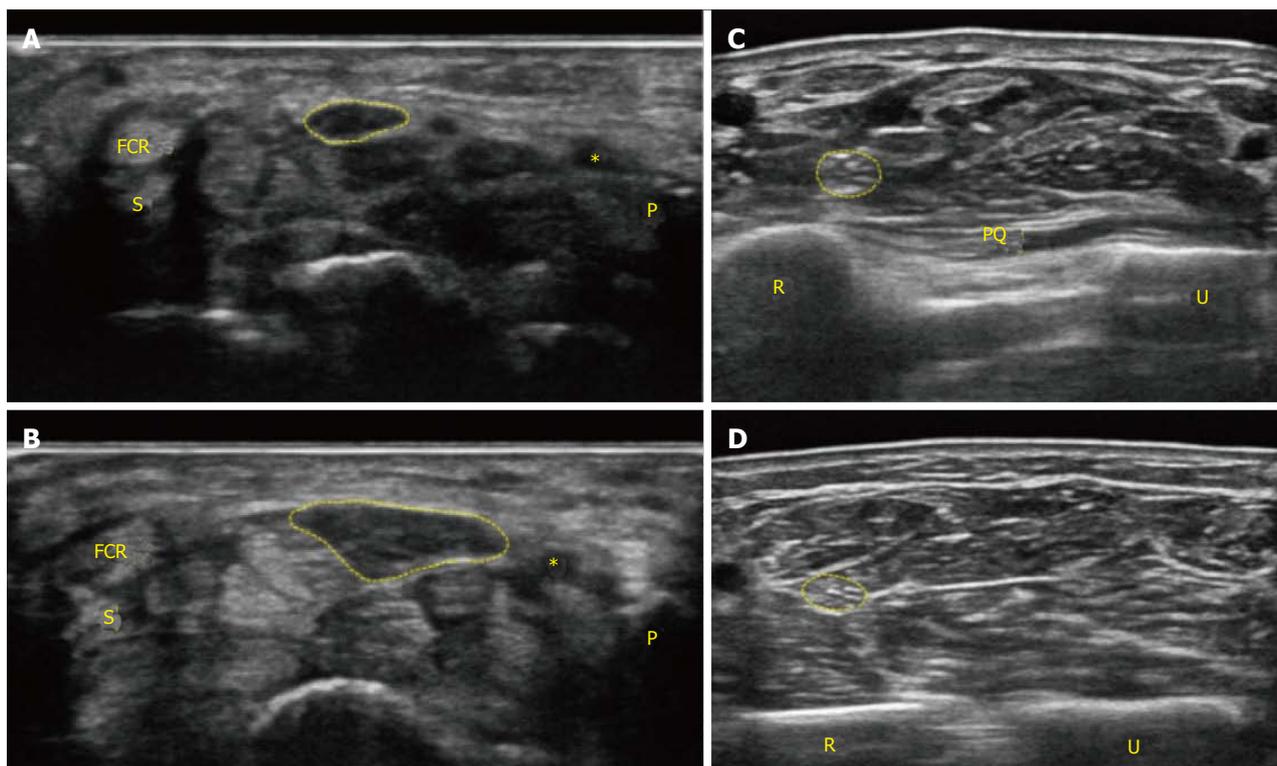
Transverse images in a 79-year-old female with carpal tunnel syndrome. A: A conventional grey scale sonographic image shows the cross-sectional area of the median nerve (CSA) corresponding to the circle in the normal side with an area of 8 mm² at the level of the pisiform bone; B: CSA in the carpal tunnel syndrome (CTS) side shows 21 mm² at pisiform bone level; C: CSA in the CTS side shows 7 mm² at the proximal third of the pronator quadratus level; D: CSA in the CTS side shows 6 mm² at a point 12 cm proximal to the pisiform bone. In this case, the calculated “delta CSA” and “CSA ratio” were 14 mm² and 3.5, respectively. *: Ulnar artery. FCR: Flexor carpi radialis; P: Pisiform bone; S: Scaphoid bone; PQ: Pronator quadratus muscle; R: Radius; U: Ulnar.
